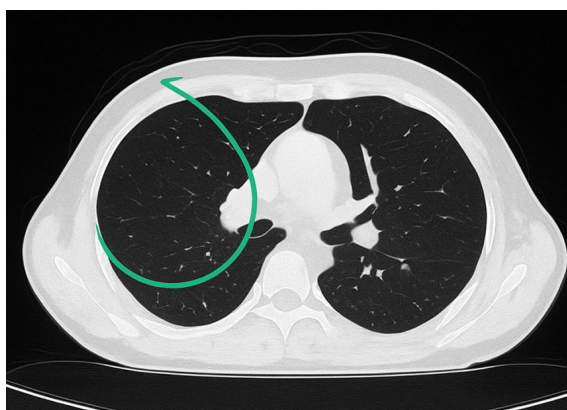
Chest CT scan April 18, 2022.
